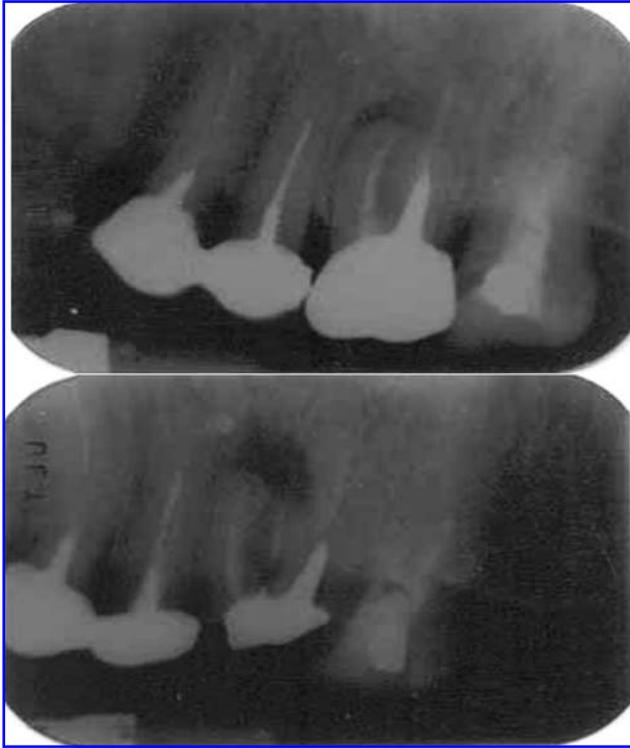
Intraoral periapical radiographs showing radiolucency at the apex of the upper right first molar root, suggestive of periapical pathosis. A cast post and core can also be seen.
